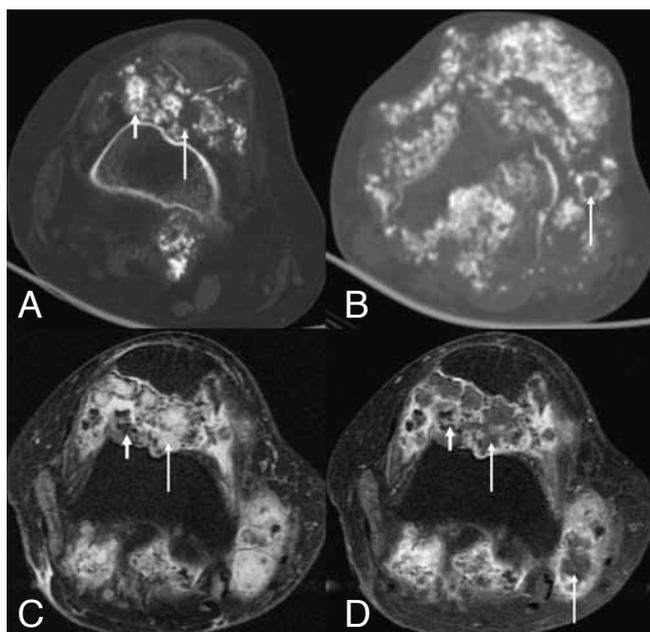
A, B. Axial CT images confirm many calcified bodies (small arrow) and central lucent nodules (long arrow) in the suprapatellar bursa and some in the posterior capsule. C. Axial proton-density and D. postgadolinium MRI images 14 months later show multiple lobular cartilaginous masses (long arrow) (corresponding to central lucent nodules on CT images), with patellar erosions, and anterior and posterior extension signal-void calcifications (small arrow).
